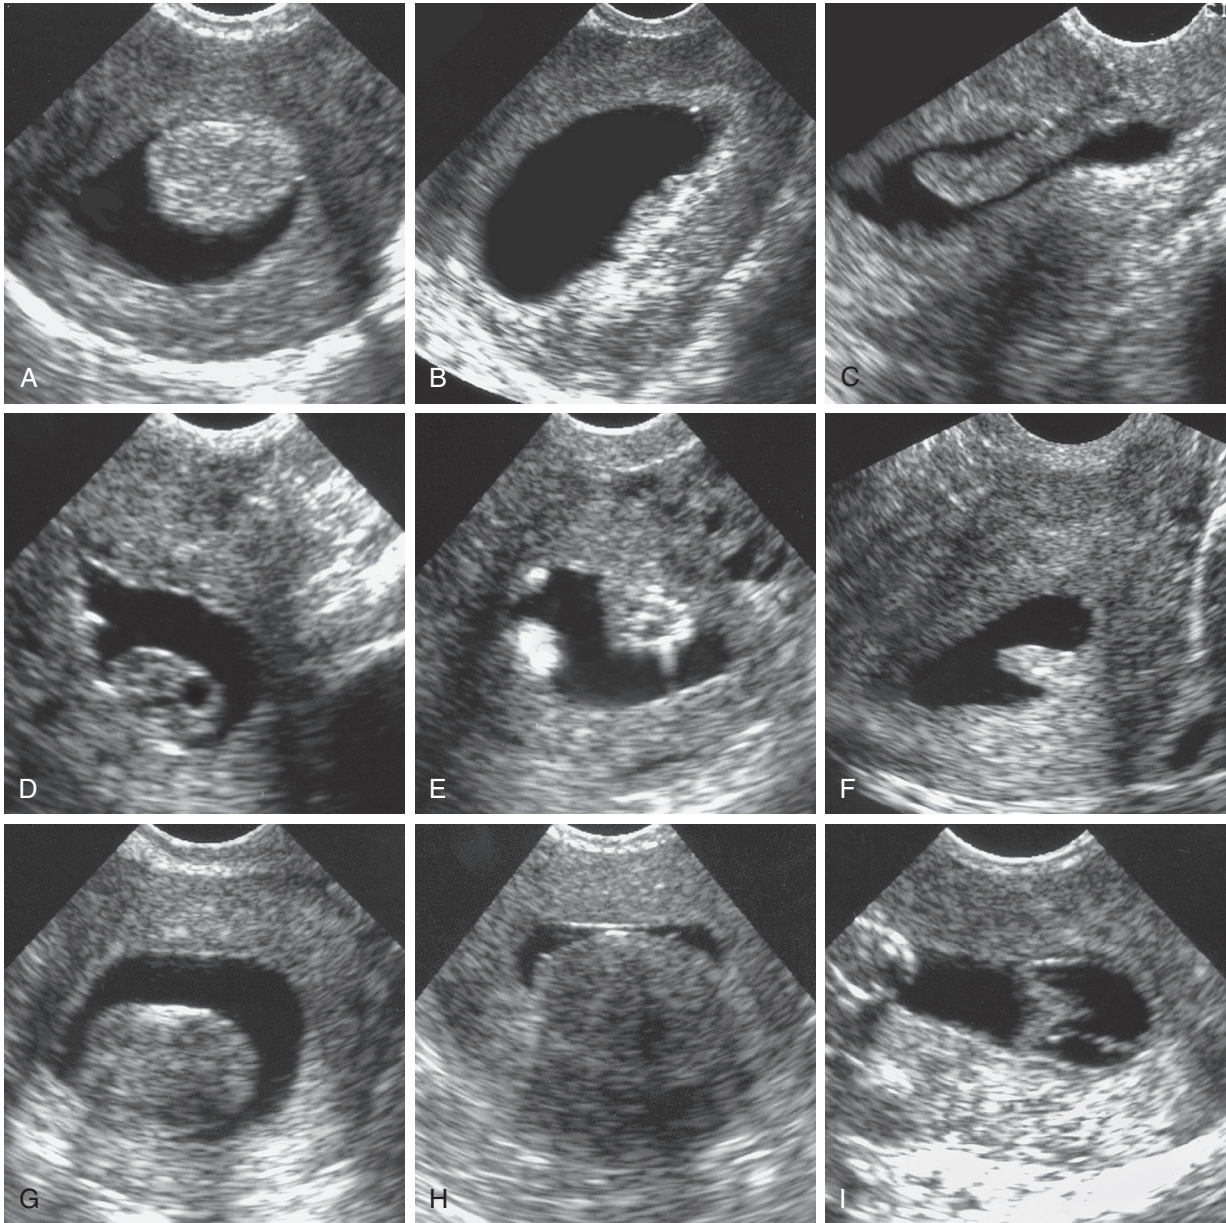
Sonohysterograms. A, Well-defined, round echogenic polyp. B, Carpet of small polyps. C, Polyp on a stalk. D, Polyp with cystic areas. E, Small polyp. F, Small polyp. G, Hypoechoic submucosal fibroid. H, Hypoechoic attenuating submucosal fibroid. I, Endometrial adhesions. Note bridging bands of tissue within fluid-filled endometrial canal. (From Salem S. The uterus and adnexa. In Rumack CM, Wilson SR, Charboneau JW, eds. *Diagnostic Ultrasound*. 2nd ed. St. Louis: Mosby; 1998:538.)
